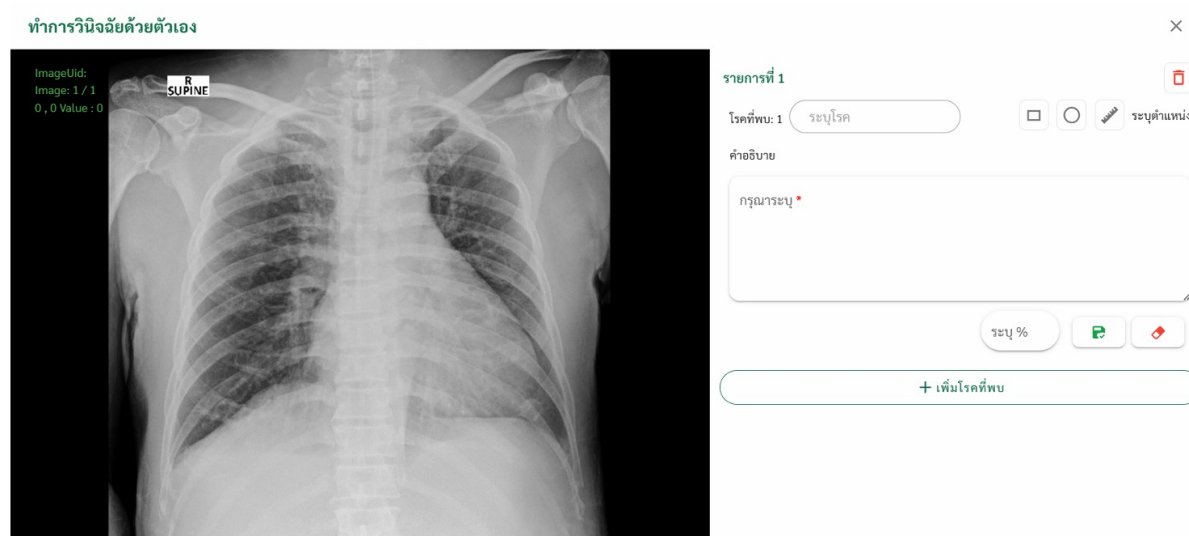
Imaging Hub panel; the image shows a Chest-X-Ray from MOPH hospitals, stored on Cloud and a panel for physicians to record their findings [16].*
